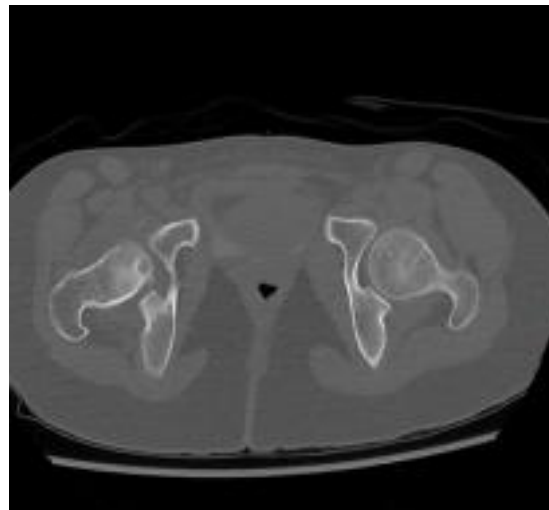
CT pelvis without contrast shows focal small lucency noted at the right femoral head -neck junction with surrounding subtle sclerosis.
